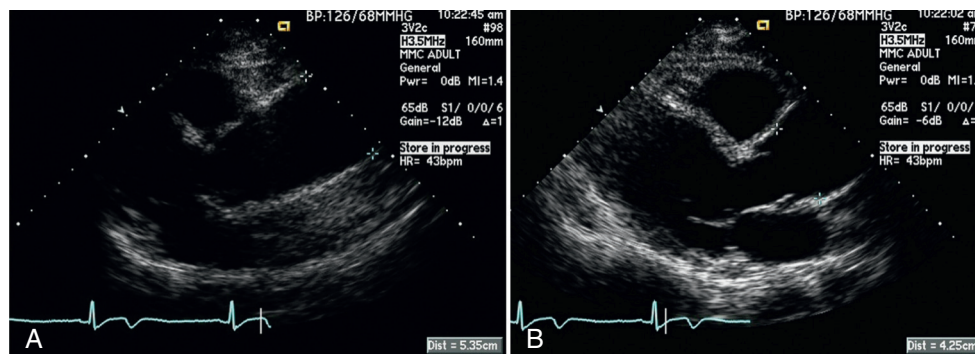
A, B, Long-axis parasternal two-dimensional echocardiographic images obtained in a 30-year-old woman with a normal functioning bicuspid aortic valve. Her ascending aorta measures 4.25 cm at the sinotubular junction (B) and 5.35 cm at the mid-ascending aorta (A). An aortic root replacement (valve-sparing) was recommended before pregnancy.
